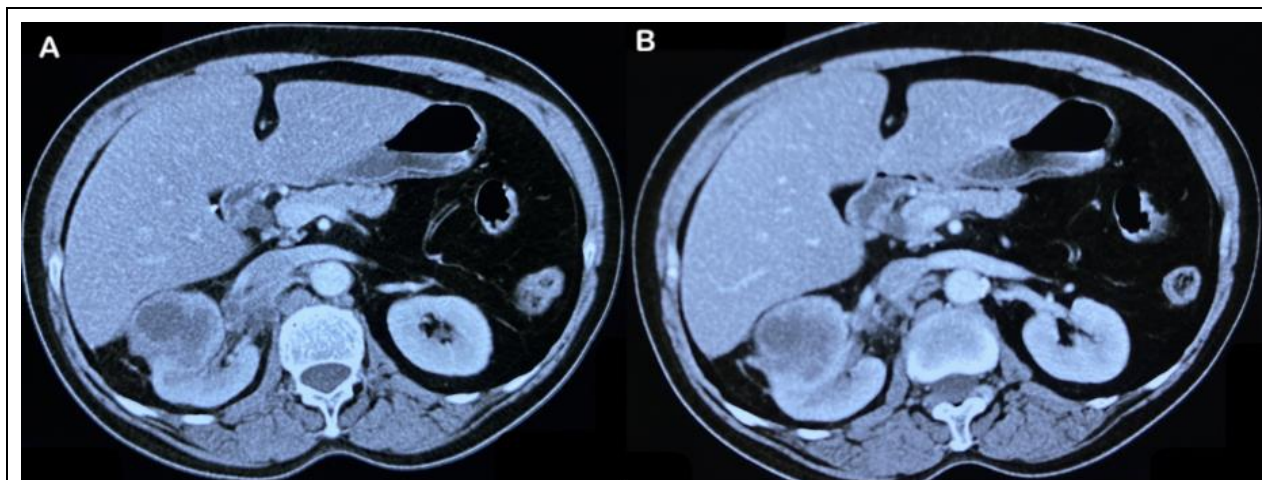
Contrast enhanced CT abdomen axial images showing heterogenous enhancing mass in upper and mid pole of right kidney with central area of necrosis.
